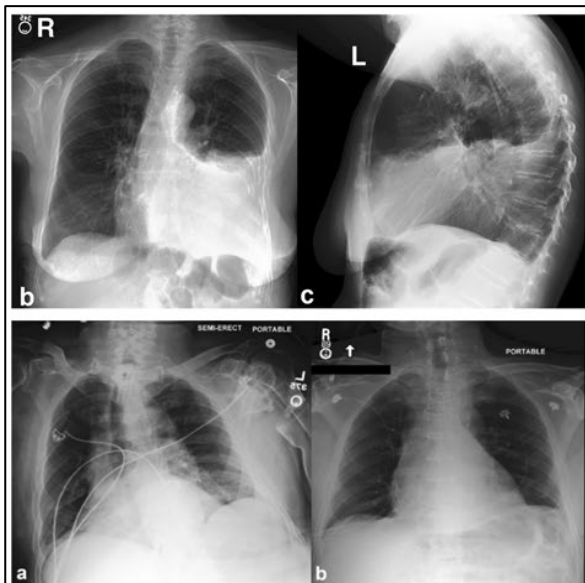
Examples of lung-disease images extracted from the Chest X-rays14 dataset.
